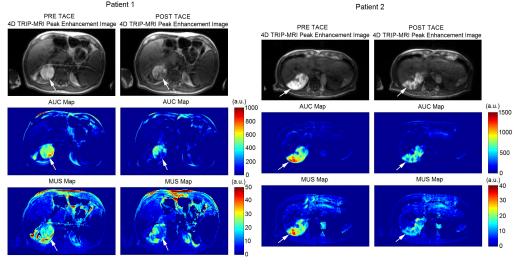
MR-IR 4D TRIP-MRI in two different patients with HCC. 4D TRIP-MRI peak enhancement images depict tumor position (arrows). Corresponding AUC and MUS maps demonstrate significant perfusion reductions following TACE.
